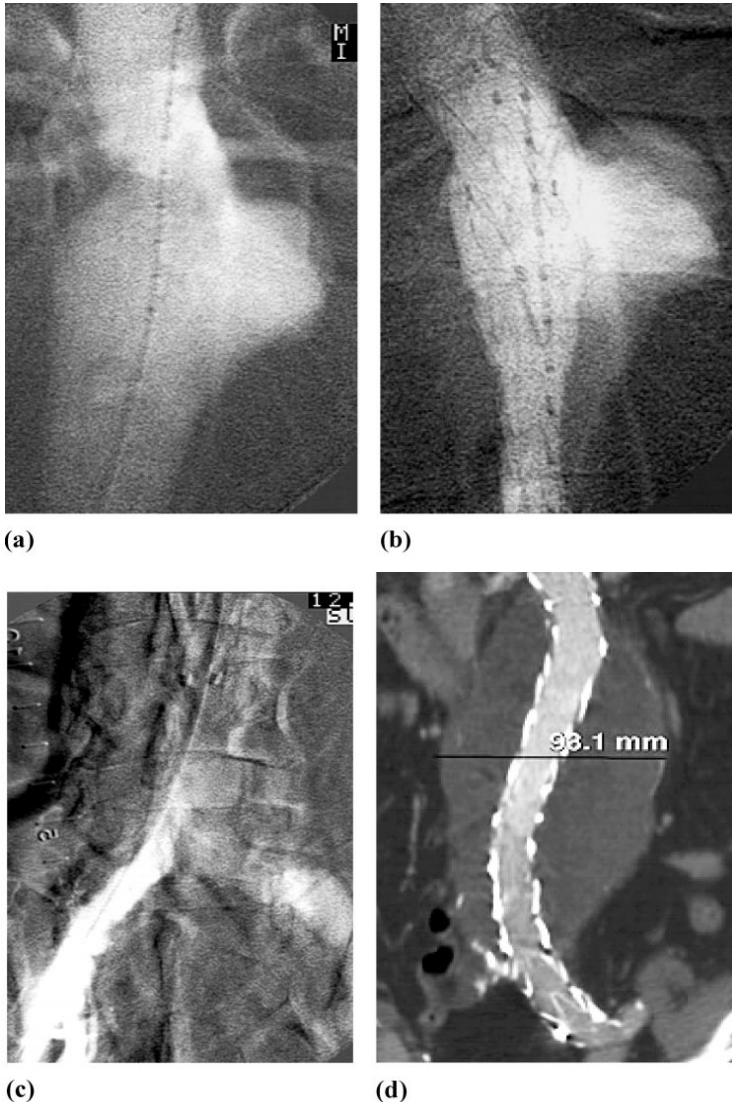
(A) Intraoperative angiogram demonstrating ruptured AAA. (B) Intraoperative angiogram demonstrating deployment of proximal component of aorto-uni-iliac device. (C) Intraoperative angiogram demonstrating bilateral iliac arteries. (D) Postoperative CT-examination, demonstrating functioning aorto-uni-iliac device with complete exclusion of the aneurysm.
